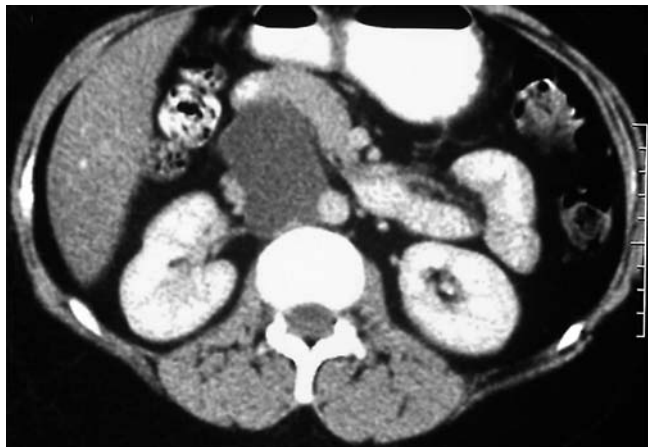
A 32-year-old woman presented with a dull aching abdominal pain of 2 months duration. A computed tomography (CT) abdominal scan revealed a 4-cm cystic lesion near the head of the pancreas.
